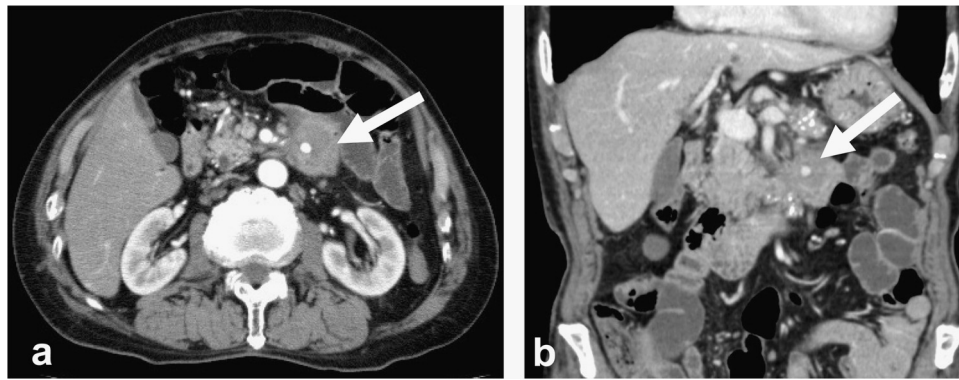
Contrast-enhanced abdominal computed tomography (CT) indicated a low density mass measuring 3.0 cm in diameter, including an enhanced spot (arrow); (a) (transverse view) and (b) (coronal view).
